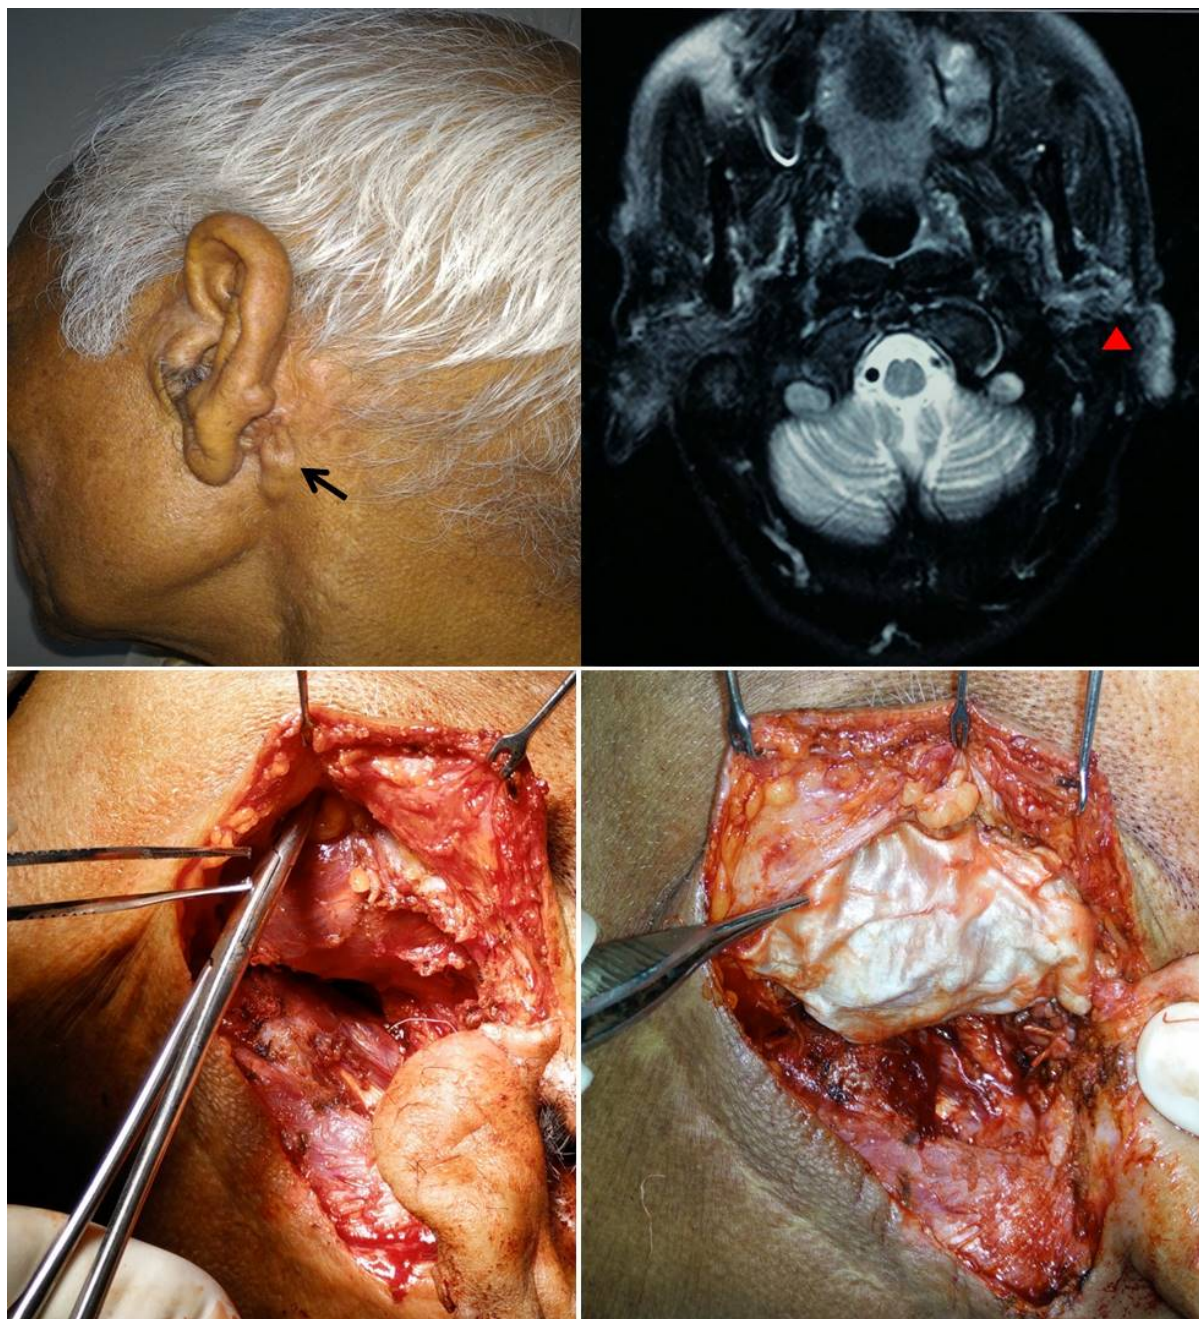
Two years post-operative. Nodular skin swellings over previous scar (arrow). MRI showing T2 hyperintense lesion extending from skin, subcutaneous tissue into deep retromandibular region (arrowhead). Intraoperative picture showing excision of recurrence followed by tensor fascia lata interposition.
